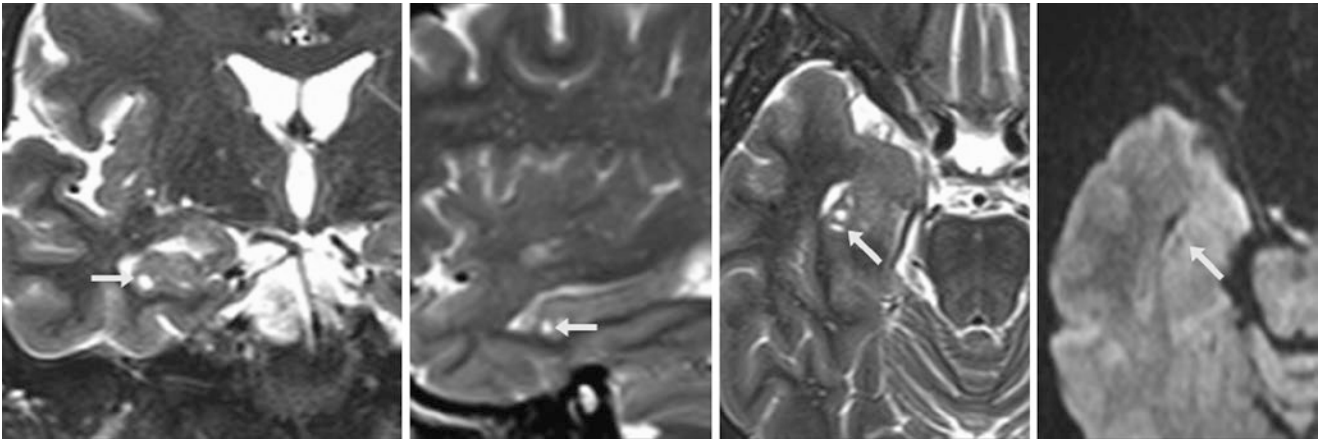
A 61 year old with 1.5 T MRI coronal (*left*), sagittal (*left middle*), and axial (*right middle*) T2WIs showing multiple right hippocampal cysts (*arrows*) with a signal akin to CSF (i.e., increased diffusivity) on DWI (*right*)
